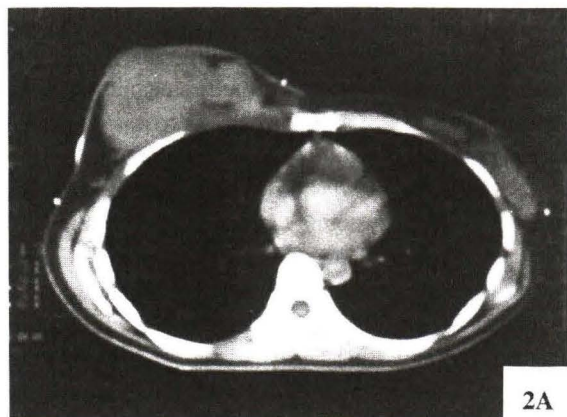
Pre-treatment axial CT scan of patient no. 12 showed large right breast mass.
